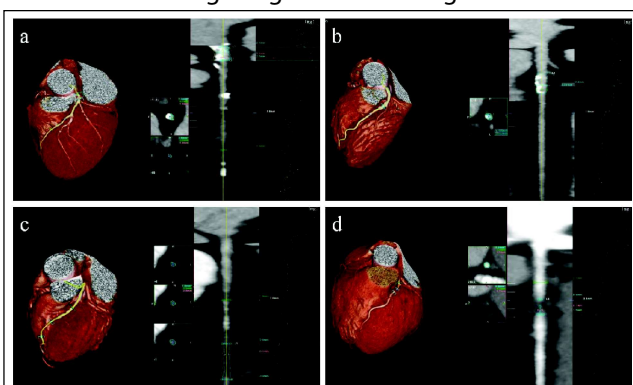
Grade of Coronary computed tomography angiography (CTA) features. a.normal appearing, b.slightly narrowed, c.moderately narrowed, d.severely narrowed.
